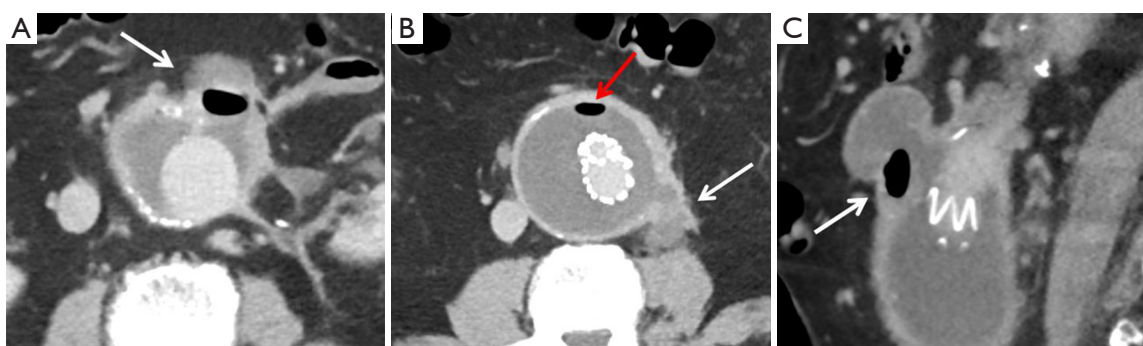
A 72-year-old man with mycotic aneurysm. (A) Axial and (C) coronal contrast-enhanced CT show a 3.4-cm saccular out-pouching (arrows) arising from anterior aspect of an infrarenal abdominal aortic aneurysm with containing air. Associated aortic wall thickening and peri-aortic fat stranding is seen; (B) axial contrast-enhanced CT image shows another 3.2-cm out-pouching (white arrow) arising from left lateral wall of the infrarenal abdominal aortic aneurysm with associated air (red arrow) within the excluded sac, aortic wall thickening and peri-aortic fat stranding.
